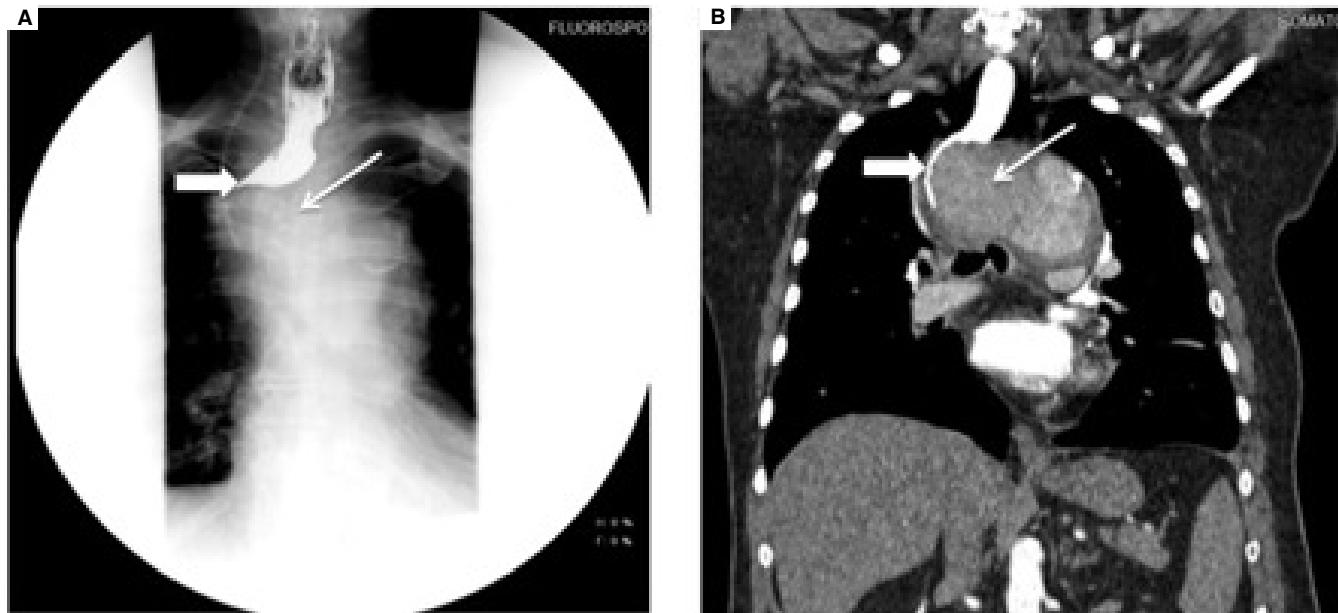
Esophageal serie (A) and CT scan (B) show mediastinal dilation and complete occlusion of the esophagus by an aortic aneurysm.
